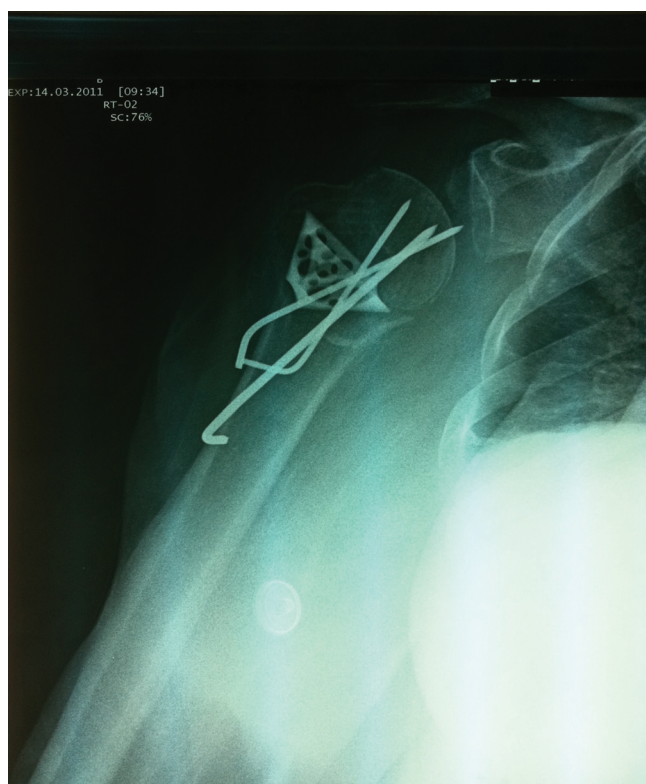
Varus fracture. (A) X-ray (B) CT- scan (C) Intraoperative bone loss (D) Cage inside and head correction (E) Cage and osteosutures (F) Intraoperative x-ray (G) 7 months x-ray control (H) 2 y x-ray control (I) 2 y clinical control (J) 7 y x-ray control (K) 7 y clinical control.
